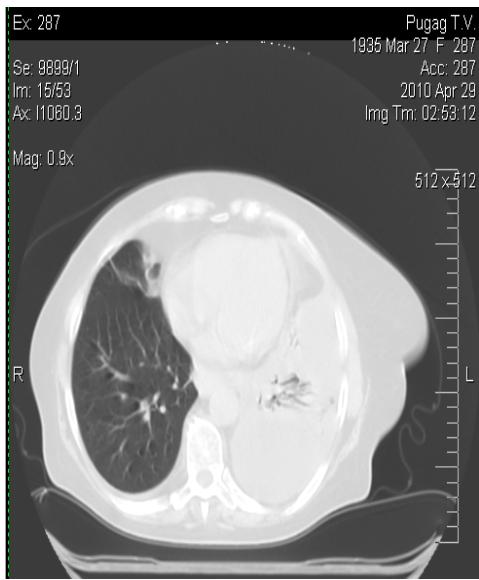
Computed tomography of left-sided pleurisy.
